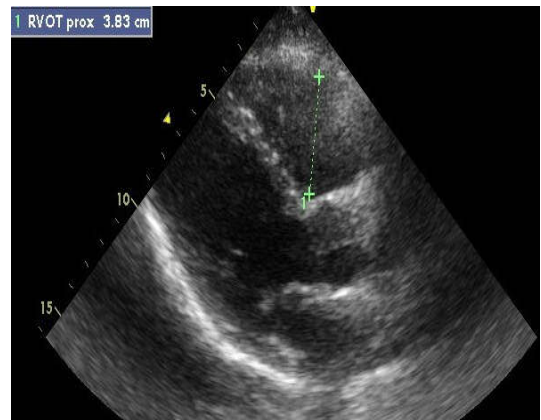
Measure of RVOT(Parasternal long axis and Parasternal short axis)
